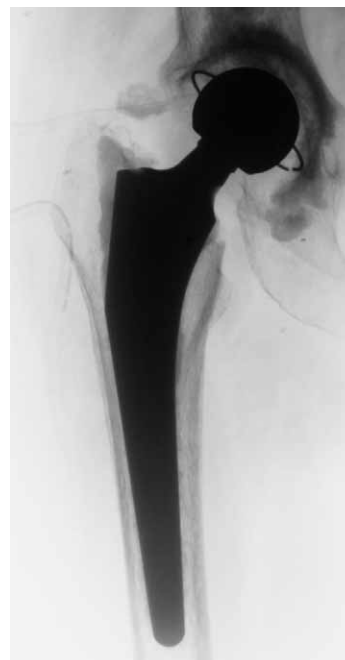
X-ray of the Müller type cemented hip prosthesis with a stem occupying <90% of femoral canal diameter: A – directly after implantation; B – loosened 5 years later.
